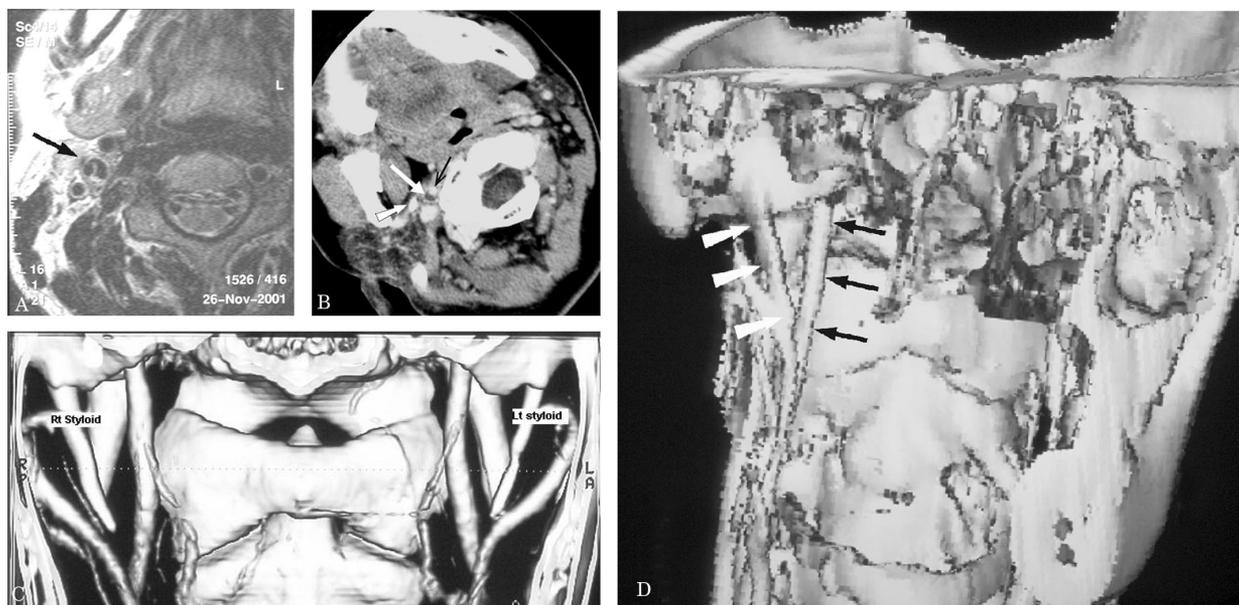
(A) MRI of the neck shows a false lumen of the right internal carotid artery opening into the true lumen (arrow). (B) Axial contrast-enhanced dynamic source image shows the subintimal hematoma (long/white arrow) between the true lumen (black arrow) and the right styloid process (short/white arrow). (C) Three-dimensional reconstruction of the CT angiogram with the head in neutral position shows a longer and broader styloid process on the right. (D) Three-dimensional reconstruction of the CT angiogram using surface-shaded display with the right mandible removed shows the elongated right styloid process (black arrows) pointing to the right internal carotid artery (white arrows) on rotation to the right.
